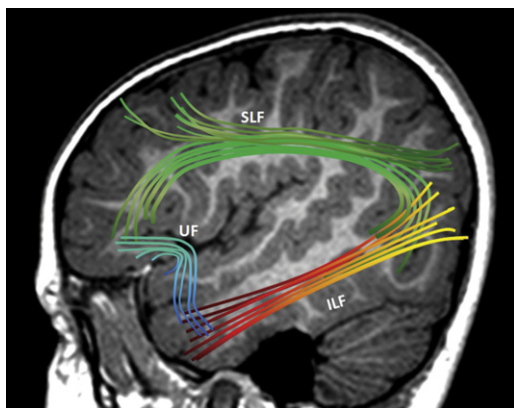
MR image demonstrating relative trajectories of the SLF, uncinate fasciculus (UF), and inferior longitudinal fasciculus (ILF) to one another.
